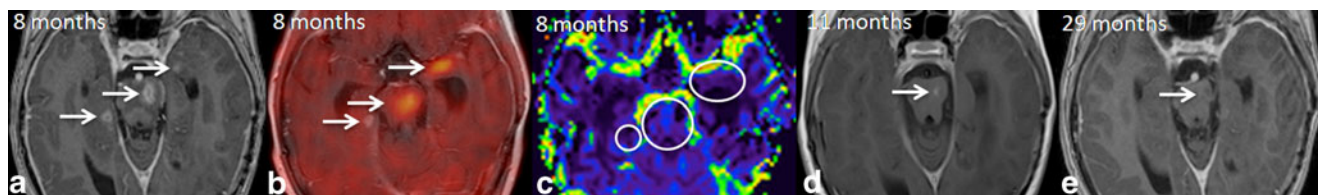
Follow-up MRI 8 months (a–c), 11 months (d), and 29 months (e) after beginning of complementary proton beam irradiation showing appearance of abnormal rim-like enhancements on T1W after gadolinium within the pons and both temporal lobes (arrows, a). The lesions show a low CBV (circles, c) and two of them are hypermetabolic on
